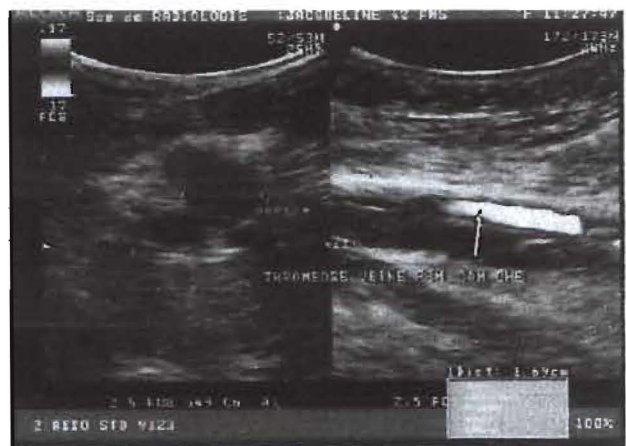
Thrombosis of left femoral vein at Doppler ultrasound (white arrow)
